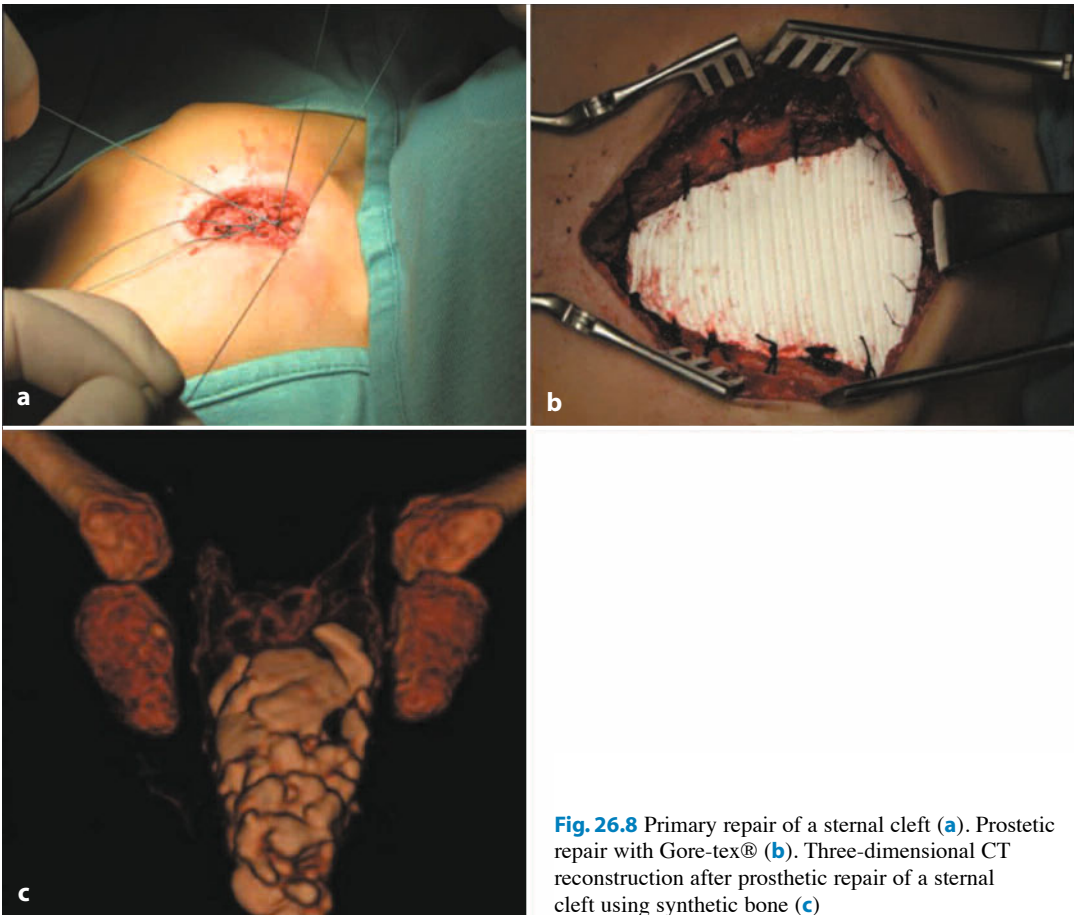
Primary repair of a sternal cleft (a). Prosthetic repair with Gore-tex® (b). Three-dimensional CT reconstruction after prosthetic repair of a sternal cleft using synthetic bone (c)
